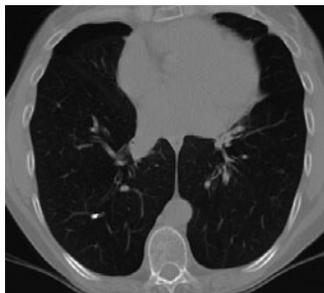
Native chest CT scan demonstrating a cement embolus in a peripheral right lower lobe pulmonary artery.
